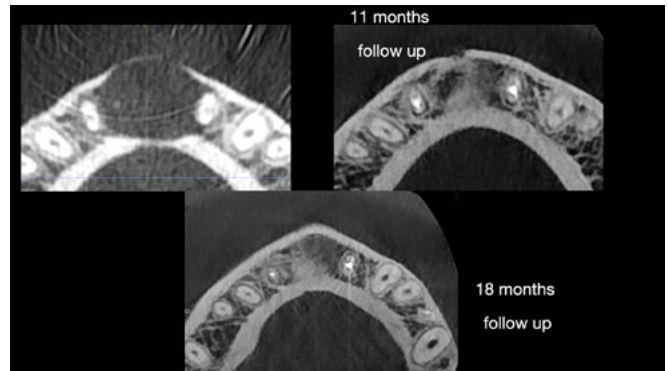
The CBCT scan shows the significant bone healing after a 11 and 18-month follow-up, and the patient was cleared for orthodontic treatment.
